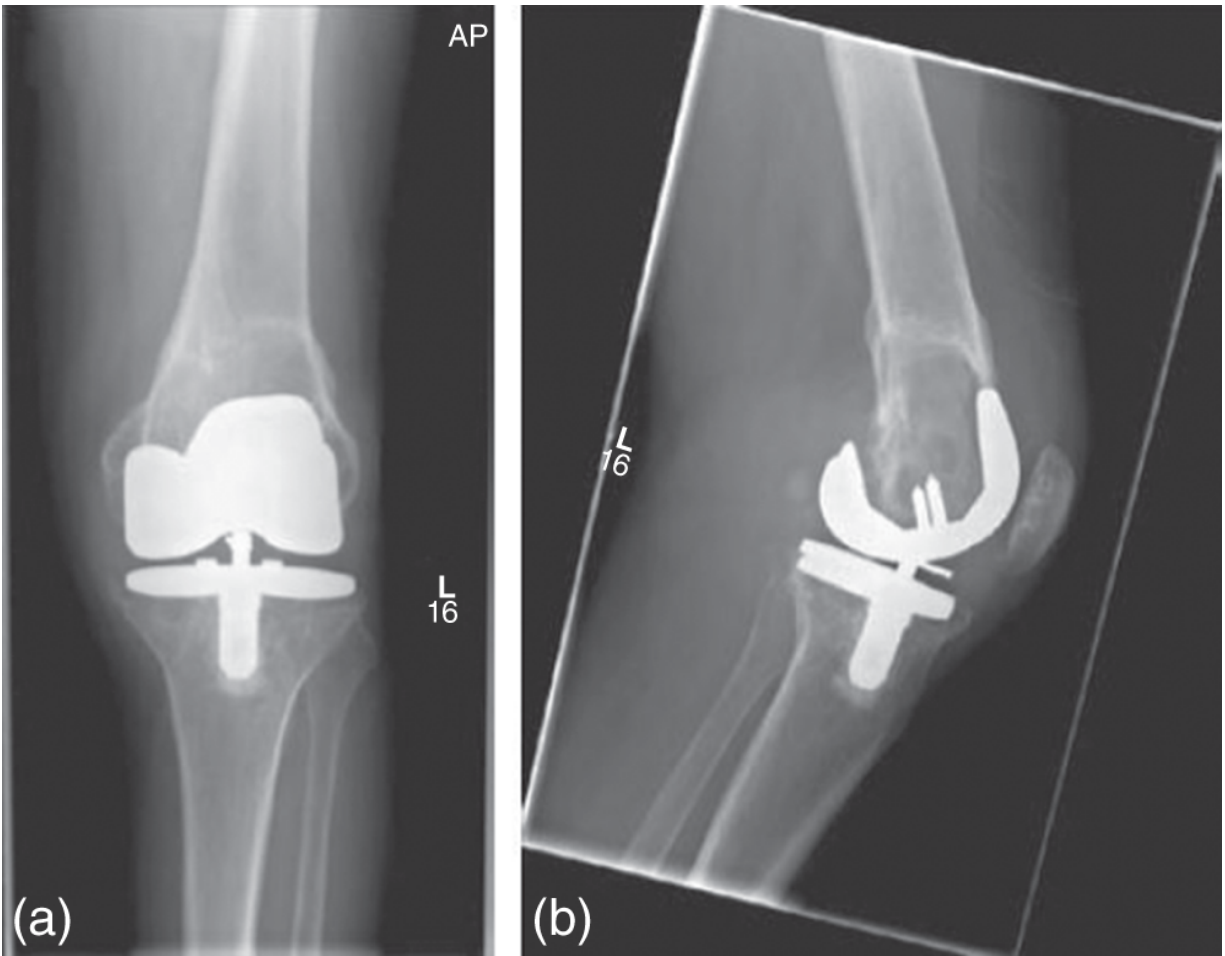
Representative radiographs of 69-year-old man with osteolysis around TKA implants. (a) Anteroposterior and (b) lateral radiographs of TKA with femoral bone loss secondary to osteolysis.
